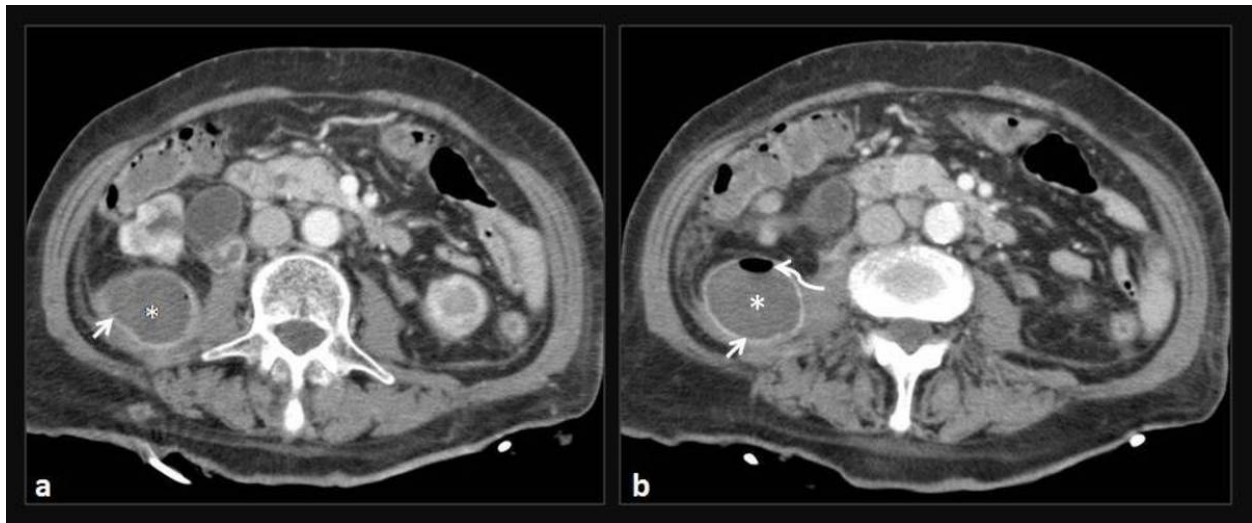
Extraparenchymal abscess. Axial CT images show a well-defined low-attenuation collection (*), with enhancing walls (arrows) and gas (curved arrow), in the right retroperitoneal region.
